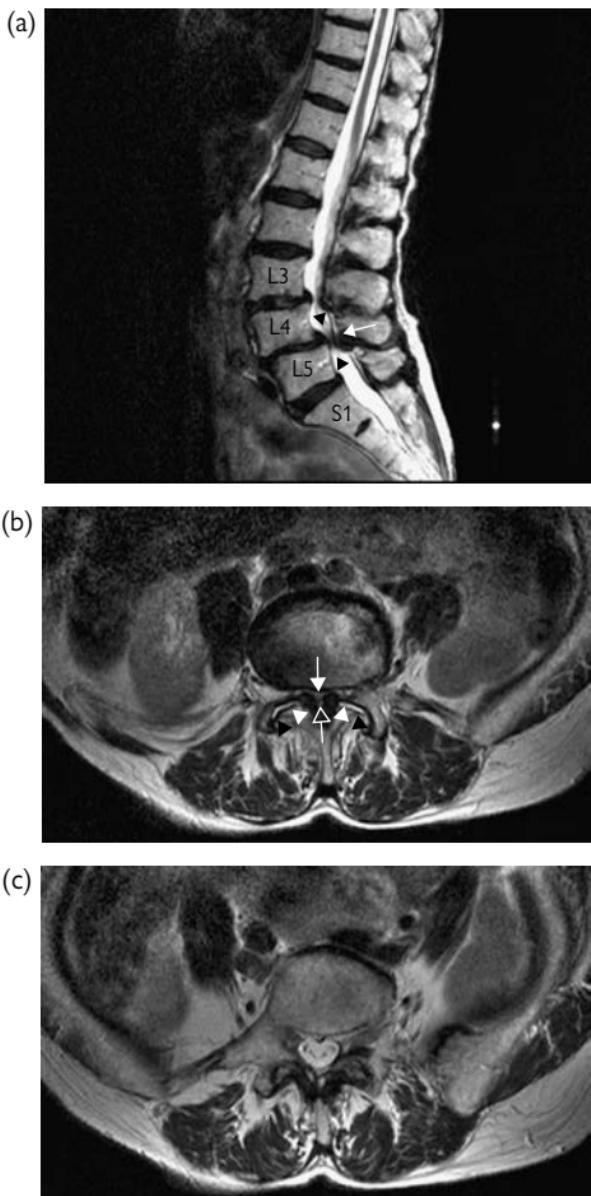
Focal lumbar vertebral canal stenosis. (a) Sagittal T2W; (b) and (c) axial T2W MRI. There is mild anterior subluxation of L4 upon L5 (Grade 1 spondylolisthesis). In conjunction with marked facet joint degeneration and thickening of the posterior ligamentous structures ((a) white arrow; ((b) white arrowheads), there is marked narrowing of the vertebral canal at this level ((a) black arrowheads) with effacement of CSF and compression of the cauda equina ((b) closed white arrow) compared to the normal appearance of the theca (c). The small area of hyperintensity posterior to the theca ((b) open white arrow) represents epidural fat rather than residual CSF.
